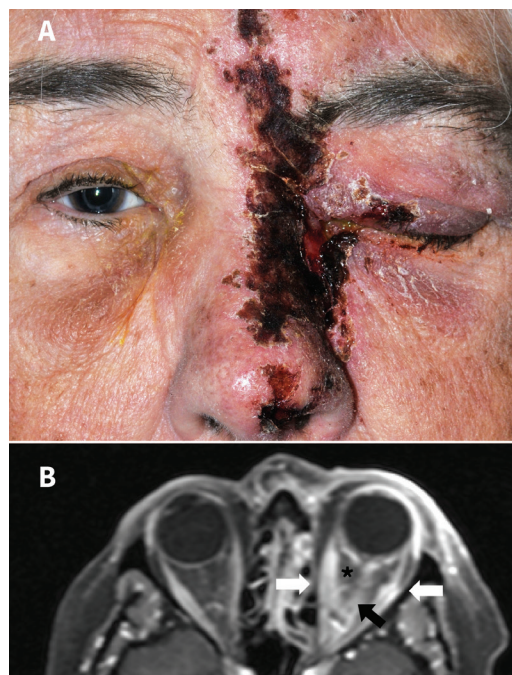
(A) Positive Hutchinson sign shown by a healing vesicular rash in the V1 dermatome on the left side of the nose of a 68-year-old woman with herpes zoster ophthalmicus. (B) T_1 -weighted magnetic resonance image (axial view) with gadolinium (fat saturated) of the same patient showing enhancement of the optic nerve (black arrow), extraocular muscles (white arrows) and fat stranding (*) within the orbital soft tissue, consistent with optic neuritis, myositis and orbital inflammation.
